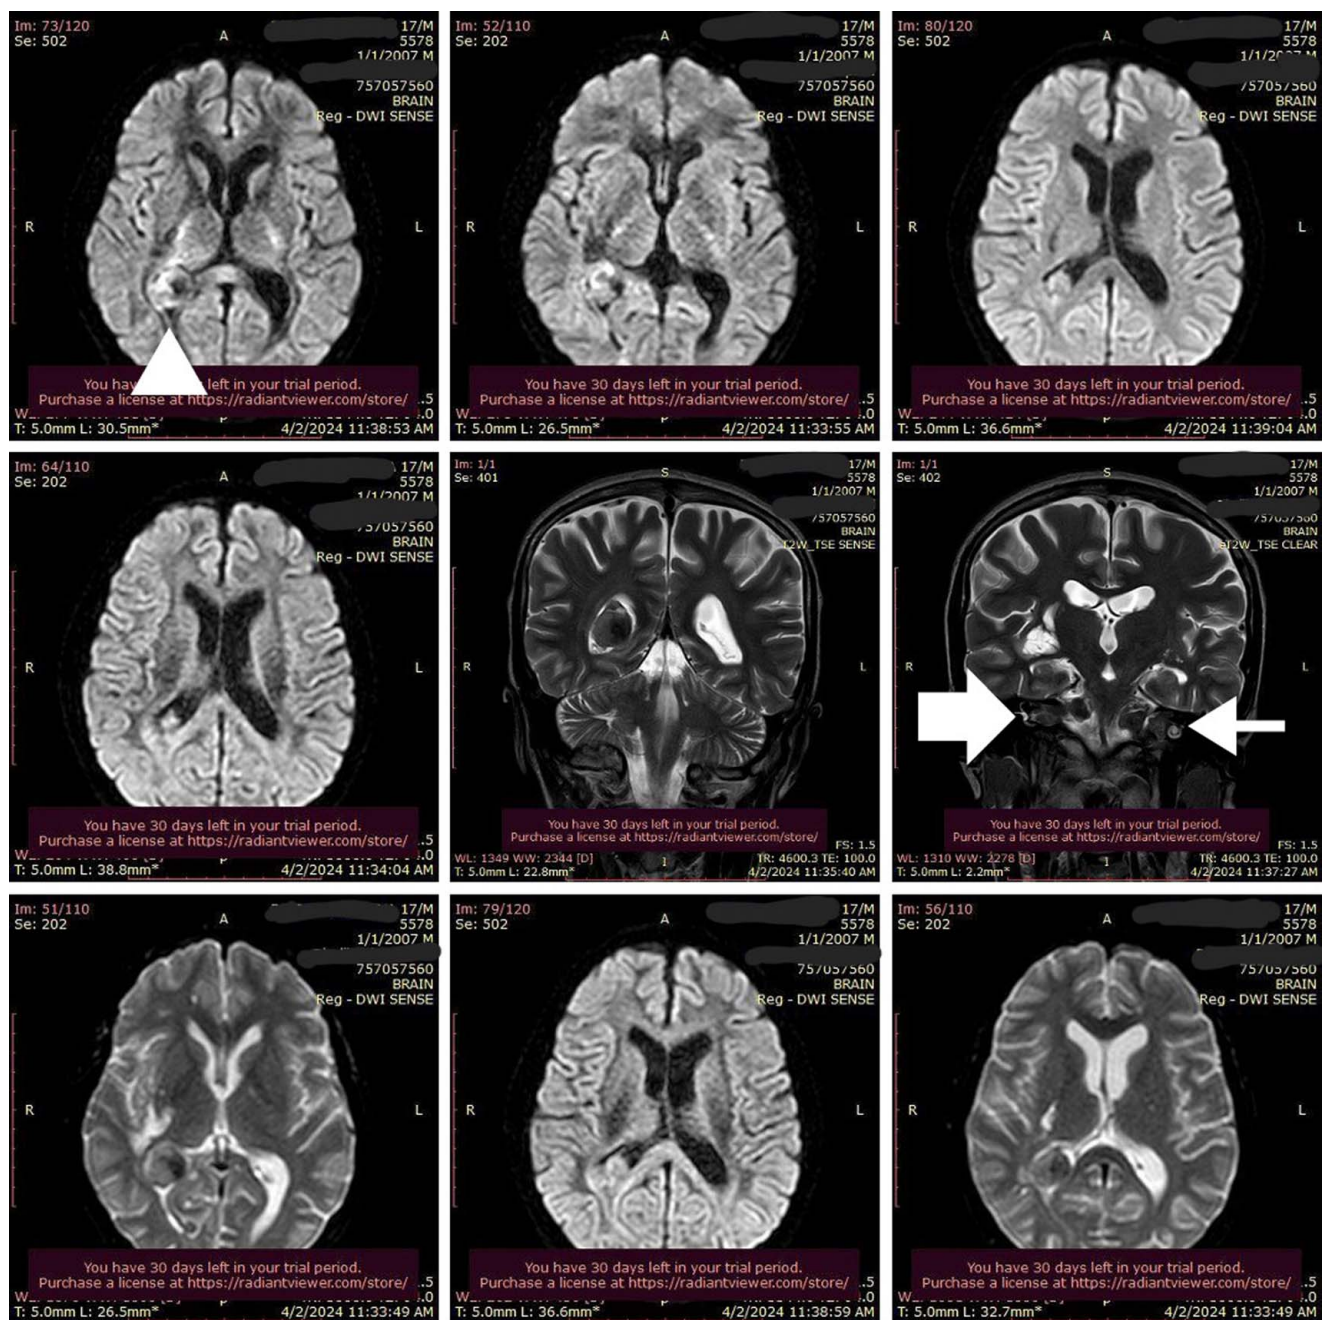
Postoperative MRI of the brain.
